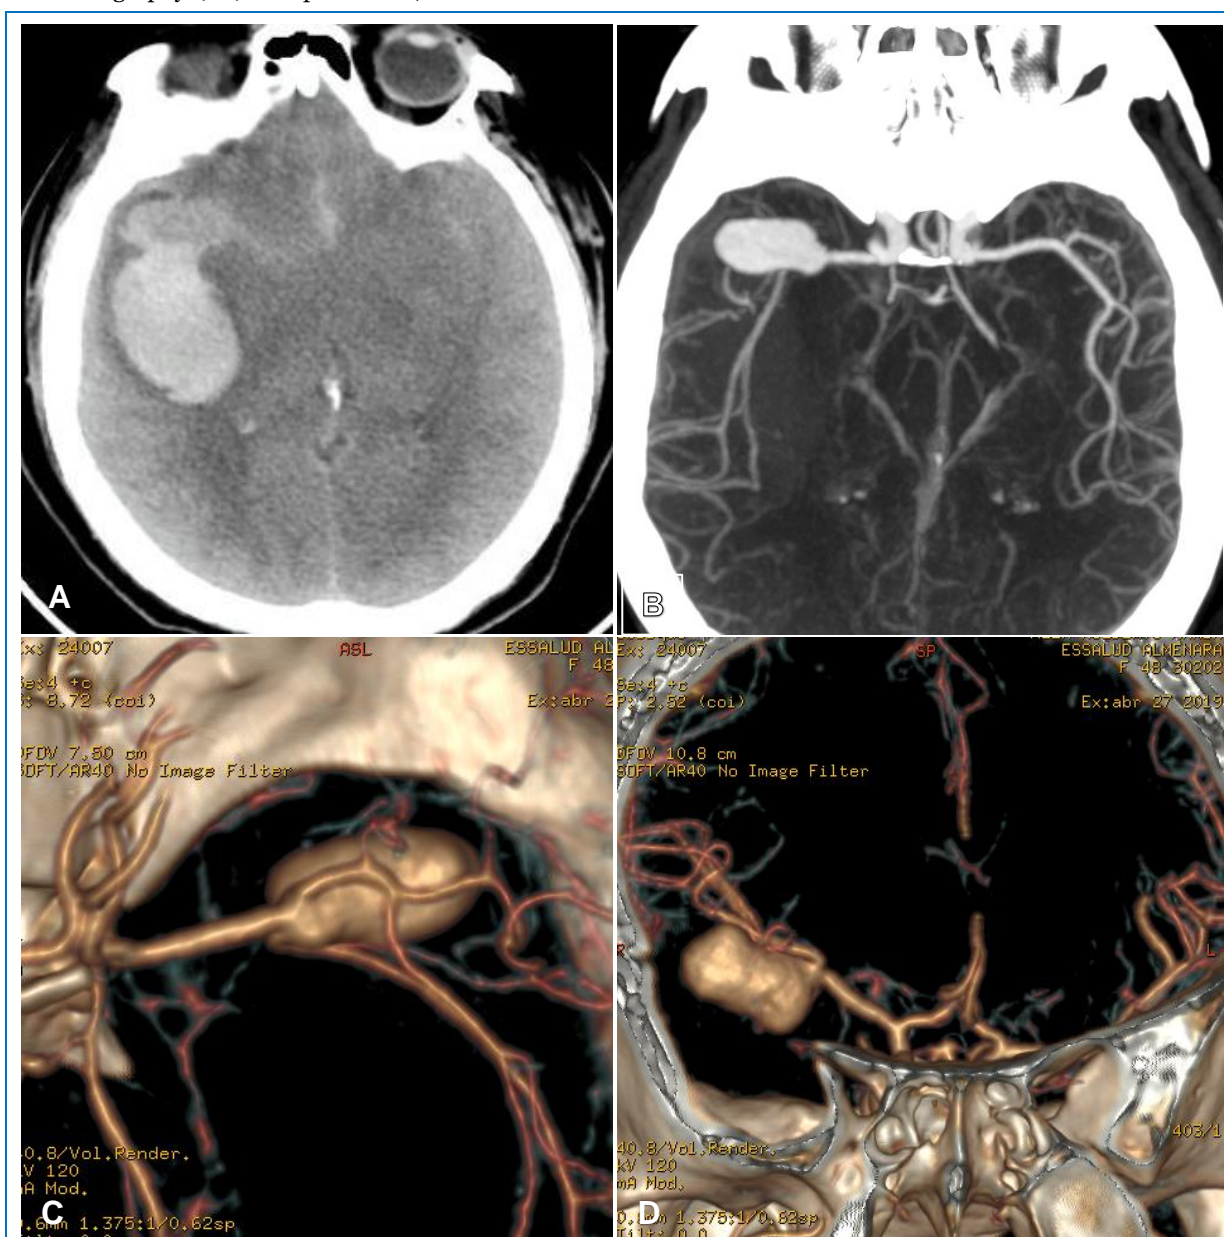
(A) Brain CT without contrast showing SAH with extensive intraparenchymal and Silvio Valley hematoma. (B) 3D reconstruction with maximum intensity projection of cerebral AngioCT demonstrating the presence of (C, D) aneurysm in the bifurcation of the multilobed ACM with incorporation of its branches in the aneurysmal neck.
